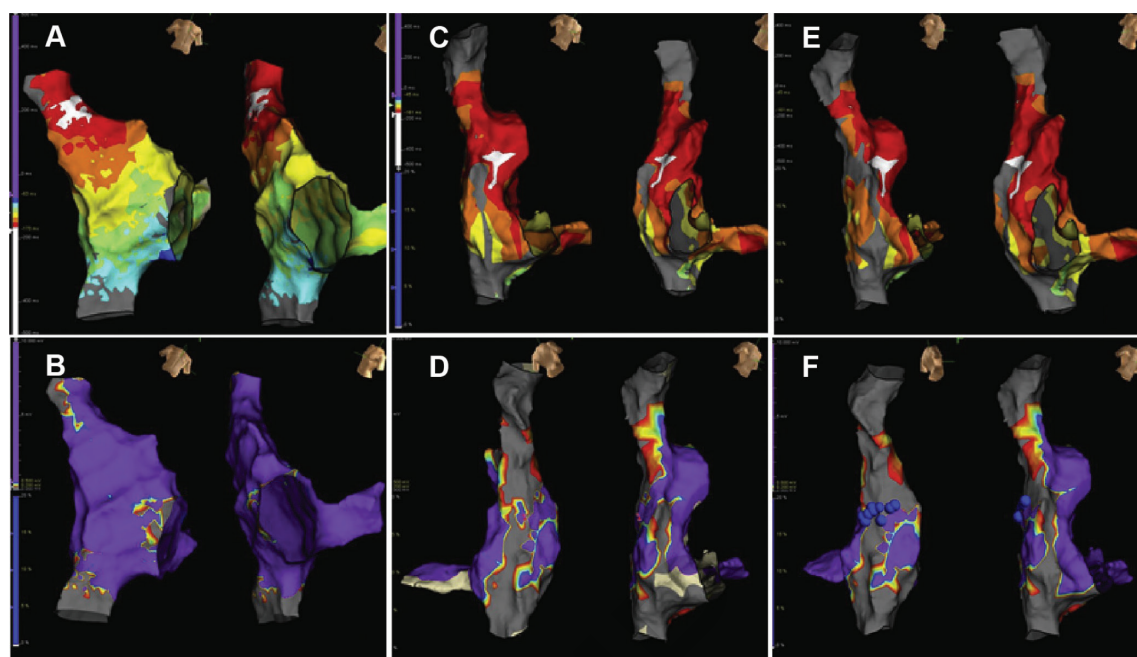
Shows the process of hybrid ablation. (A) White region represents area of earliest sinus node (SN) activity. (B) A relatively healthy right atrium (RA) on voltage mapping. (C) A downward shift in earliest SN activity along the anterolateral aspect of the RA. (D) A gap is noted in the crista terminalis (CT) lesion set. (E) Earliest SN activity seen in white after completion of superior vena cava (SVC)-inferior vena cava (IVC)-CT line lesion sets. (F) Scar manifestation on voltage mapping after SVC-IVC-CT line lesion sets.
